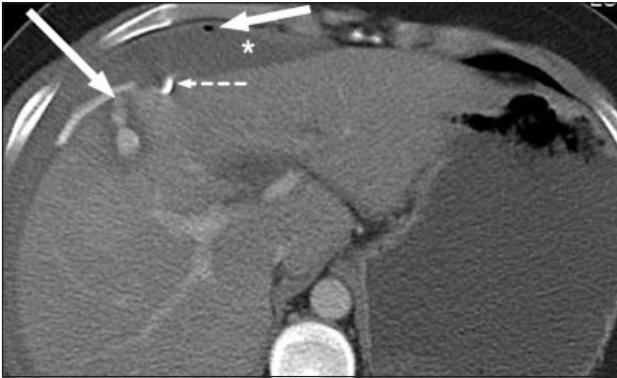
Liver laceration following a bullet injury. Axial computed tomography scan shows haemoperitoneum (asterisk), free intra-peritoneal air (short arrow), a metallic pellet on the liver surface (dotted arrow), and contrast material extravasation (long arrow).
